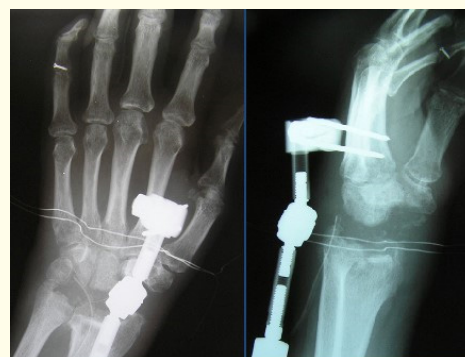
Postoperative X-ray after proximal row carpectomy and external fixation.
